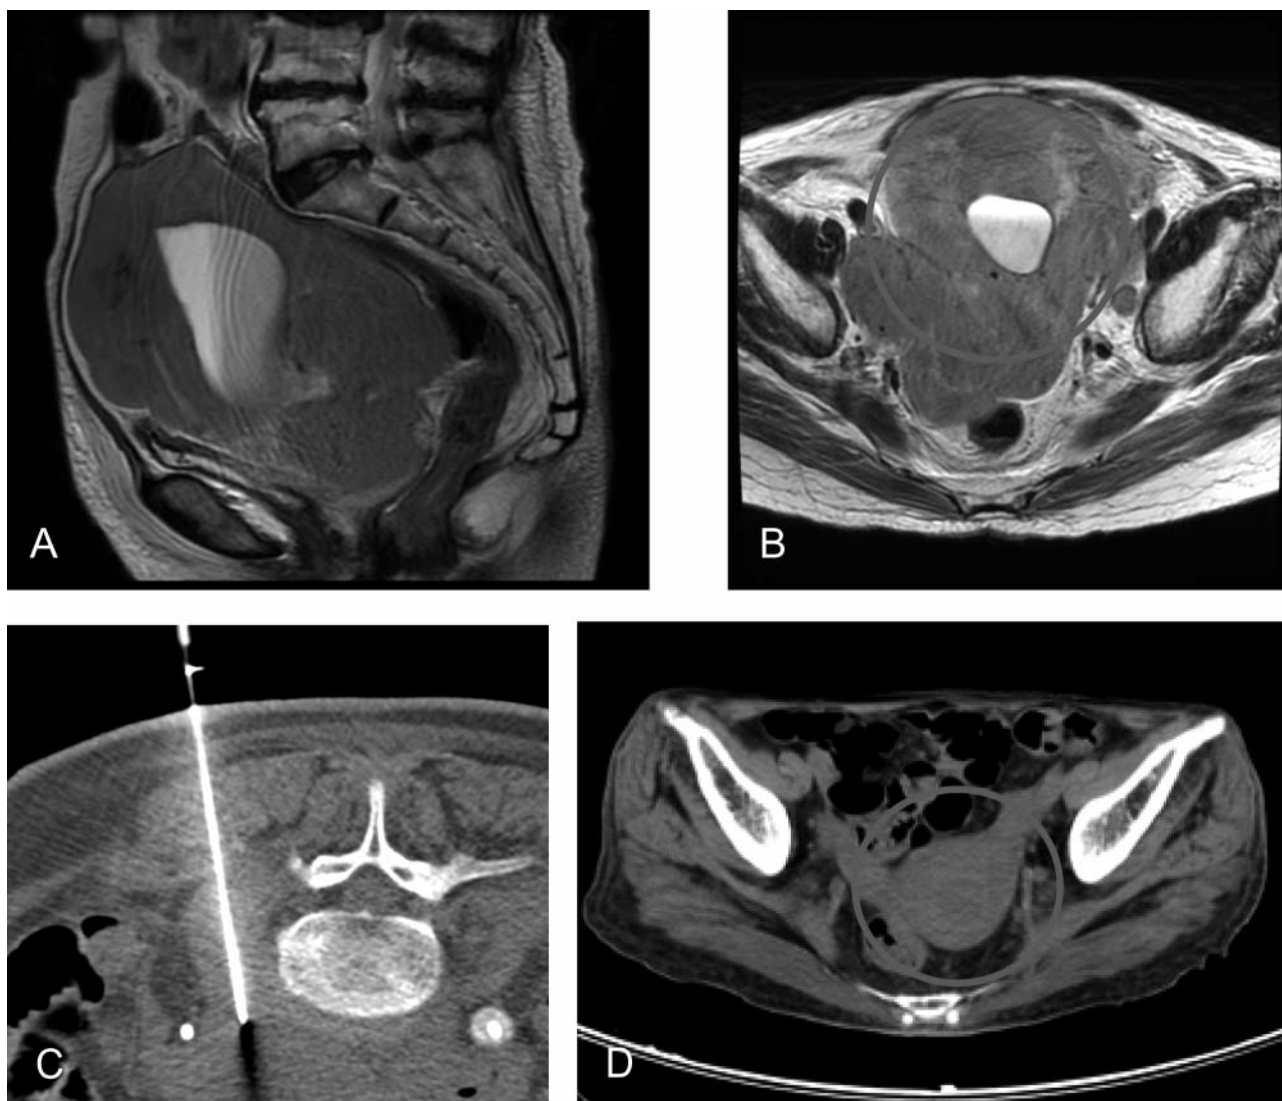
Imaging findings, Case 3. (A) Sagittal view and (B) axial view: MRI. (C) CT-guided para-aortic lymph node biopsy. (D) Follow-up CT showing a reduction in tumor size after chemotherapy.
